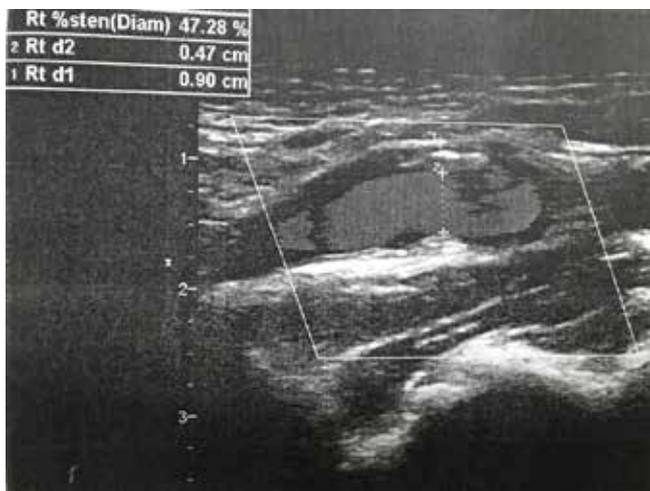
Doppler ultrasound of the carotids - first presentation of the patient
